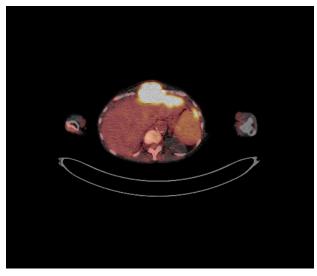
Positron emission tomography (PET) scan of whole body. We performed PET/CT at the time of 1 hour and 2 hours after the administration of the fluoro-deoxy-glucose (FDG). Blood glucose level was 111 mg/dl. Strong accumulation of FDG was observed in the tumor of the liver surface from the anterior abdominal wall.
